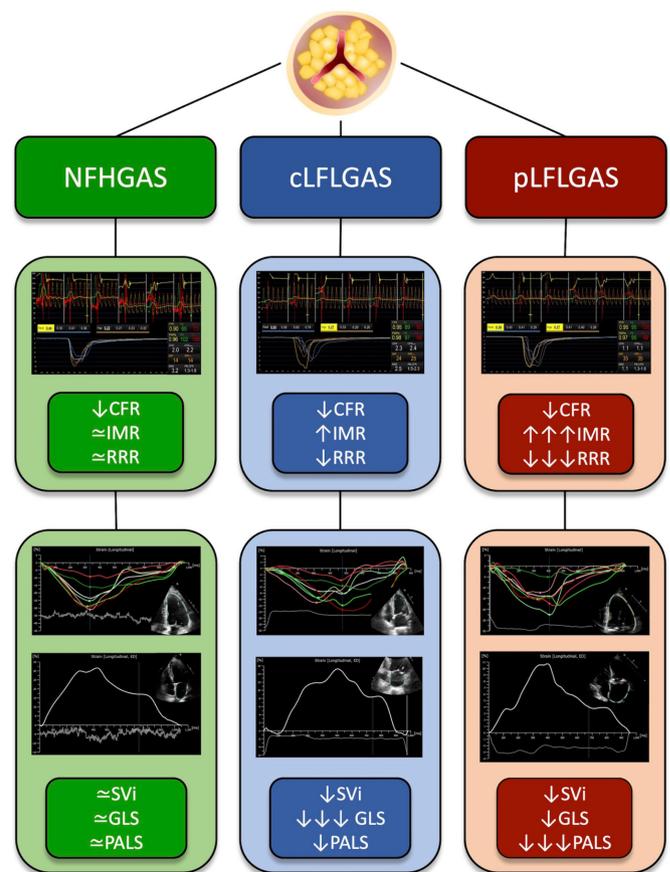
Microcirculatory and echocardiographic featuring of patients with aortic stenosis. Combining invasive coronary microcirculatory assessment and advanced echocardiographic measures of cardiac function three main AS phenotypes were delineated. *Presentation with NFHGAS*: with preserved LV function, normal or mildly impaired GLS, infrequent atrial dysfunction, reduced CFR but normal or only mildly augmented IMR. *Presentation with cLFLGAS*: with overt LV dysfunction, severe depression of GLS, concomitant moderate atrial dysfunction, reduced CFR and intermediate values of IMR. *Presentation with pLFLGAS*: with preserved LVEF, depressed GLS, severe atrial dysfunction and CMD with reduced CFR, high IMR and low RRR. CFR, coronary flow reserve; cLFLGAS, classical low flow low gradient aortic stenosis; GLS, global longitudinal strain; IMR, index of microcirculatory resistance; pLFLGAS, paradoxical low flow low gradient aortic stenosis; NFHGAS, normal flow high gradient aortic stenosis; PALS, peak atrial longitudinal strain; RRR, resistive reserve ratio; SVi, stroke vol index.
